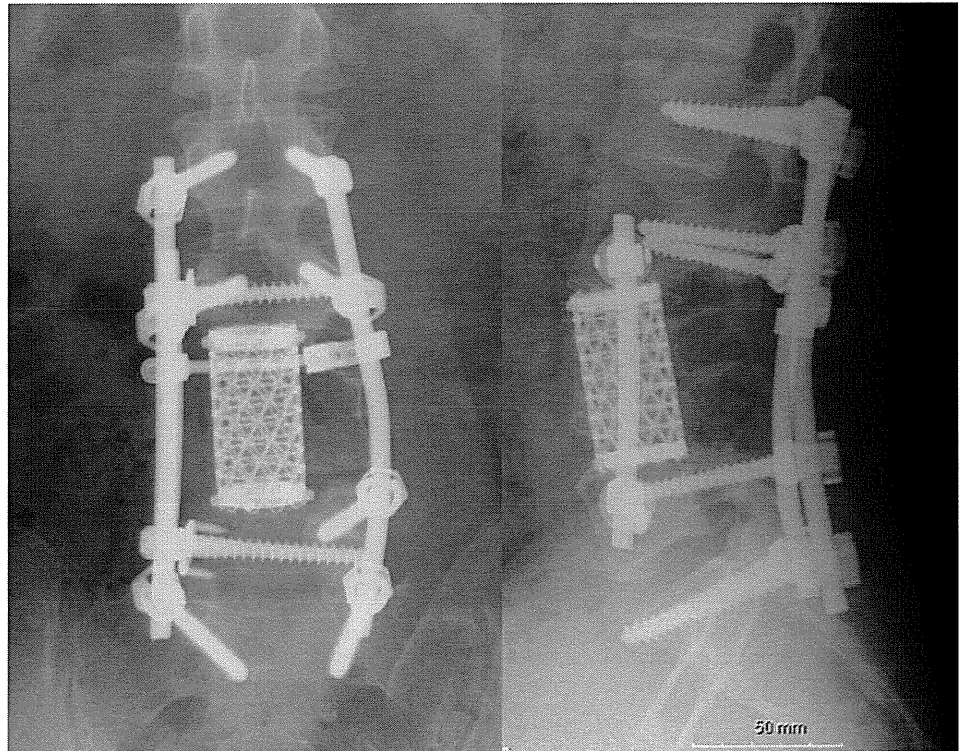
Case 2. Anteroposterior and lateral radiographs at the 1-year postoperative follow-up showing spinal reconstruction after *en bloc* tumor resection and solid bony union.
